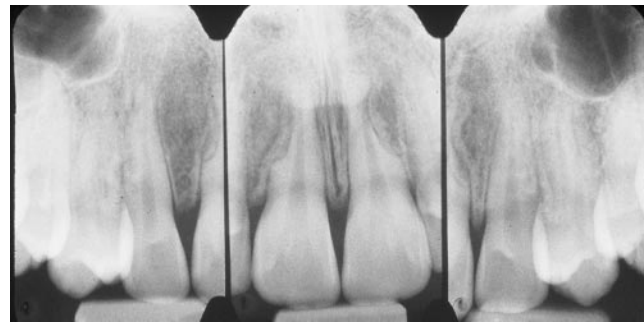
Final periapical radiograph of maxillary central incisors.
